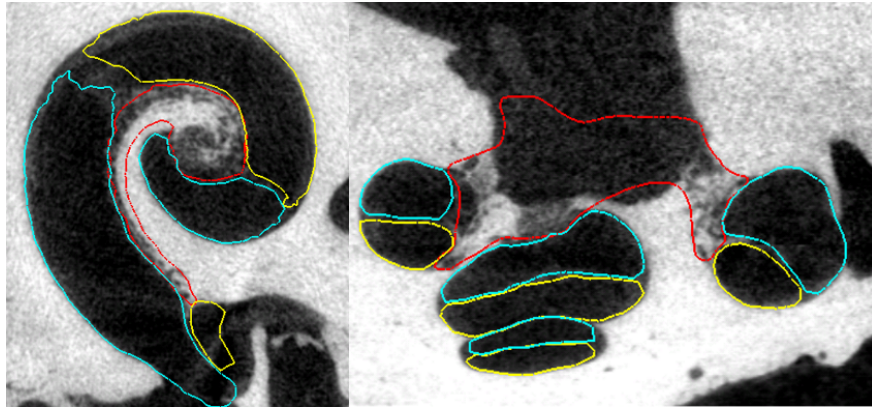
Two different view of a cropped μ CT image where scala tympani (ST), scala vestibuli (SV), and modiolus are represented with light blue, yellow, and red contours, respectively.
